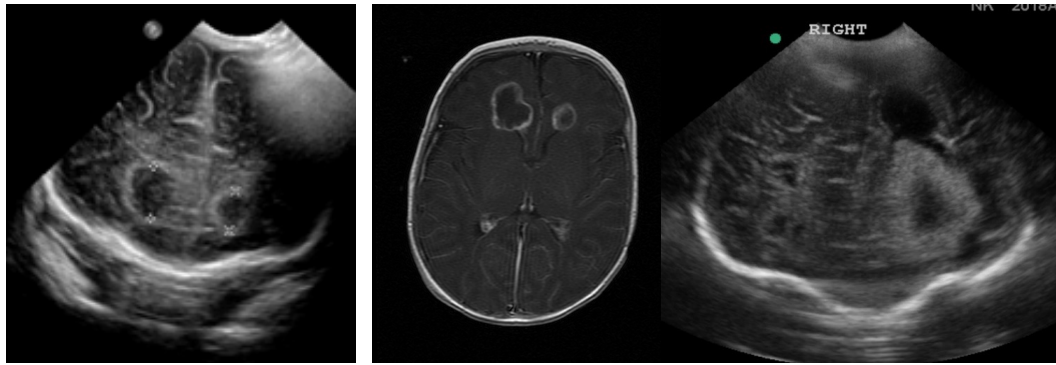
Two cerebral abscesses in the frontal region seen as two fluid filled cavities (*) on cranial ultrasound (a), confirmed on MRI (b) (Aljubaisi et al., 2015). A large left frontal lobe abscess on cranial ultrasound with central echolucency, surrounded by echogenic rim (c) (Credit K Burgoine).
